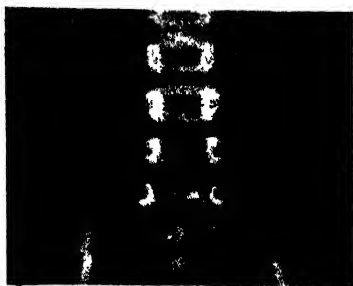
Radiograph showing calcified tuberculous lymph nodes of the mesentery. (Dr. H. R. E. Wallis, Bath.)
